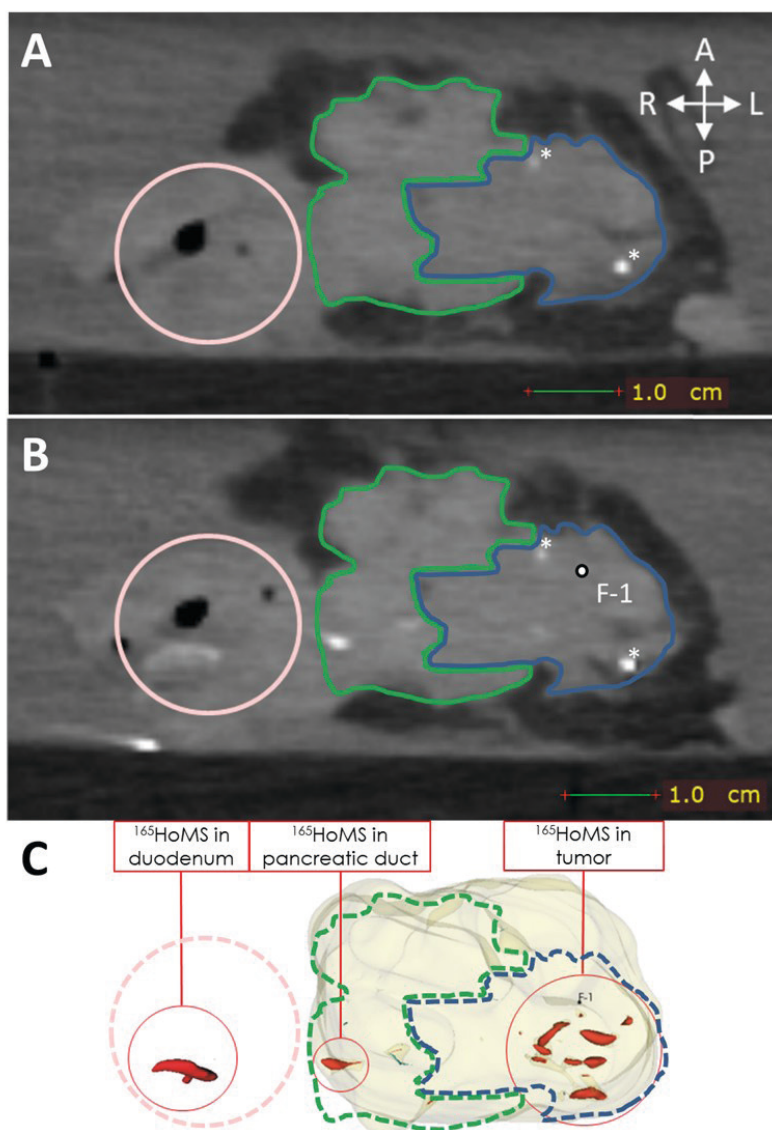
CT (0.5 mm isotropic) of intratumoral $^{165}\text{HoMS}$ injection in ex vivo pancreatic cancer sample 9 (vertically aligned). (A) CT before $^{165}\text{HoMS}$ injection showing the patient's anterior (left), posterior (right) (white arrows), duodenum (pink circle), tumor border approximation (blue contour), and healthy pancreas border approximation (green contour). (B) CT scan directly following the injection of 13.4 mg of $^{165}\text{HoMS}$ in a 0.7 mL suspension with the needle removed. Leakage of the $^{165}\text{HoMS}$ occurred from the injection location (F-1, out of plane) through the pancreatic duct toward the duodenum. (C) Three-dimensional segmentation of the pancreatic head (beige), including the healthy pancreas and tumor, and the $^{165}\text{HoMS}$ (red).
